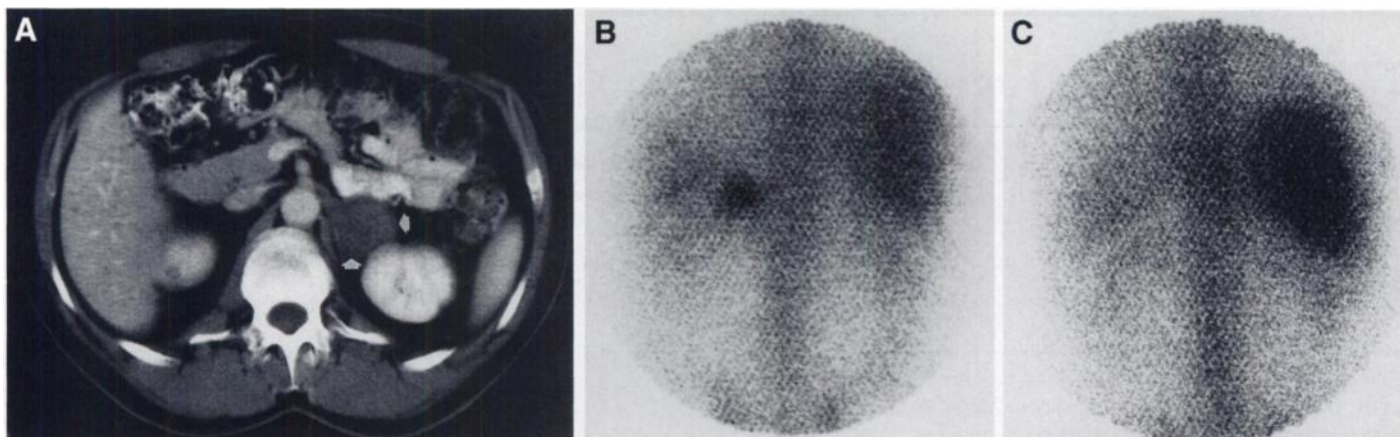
Post-treatment imaging. (A) CT shows significant decrease in the size of the left suprarenal mass (arrows). (B) Gallium scintigraphy shows significant reduction in radiotracer uptake in the left upper quadrant consistent with response to therapy. (C) Gallium scintigraphy 1 yr after treatment showing no abnormal radiotracer uptake in the left upper quadrant consistent with remission. Note normal physiologic renal activity bilaterally.
